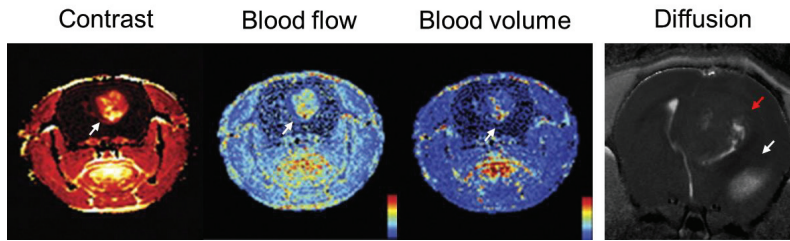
Examples of MRI perfusion and diffusion parameters
